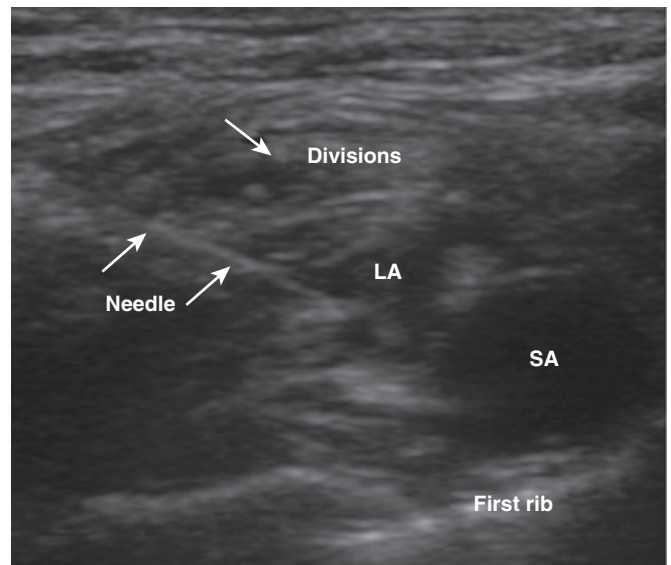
Ultrasound-guided supraclavicular nerve block. The brachial plexus is approached at the level of the divisions; the needle is entering the view from the lateral aspect at the top left of the screen. The pulsations of the subclavian artery (SA) are visualized, as is the spread of local anesthetic (LA).
